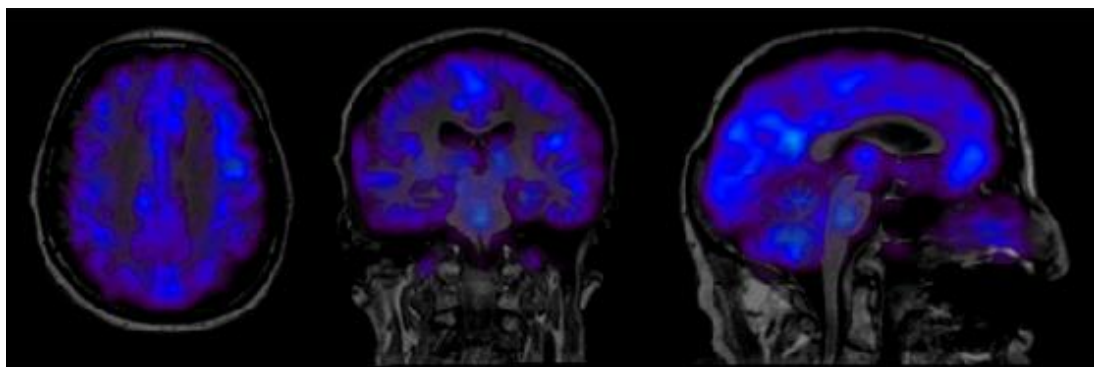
Parim Generated in AMIDE Representing VD Co-Registered with MRI Scan.
